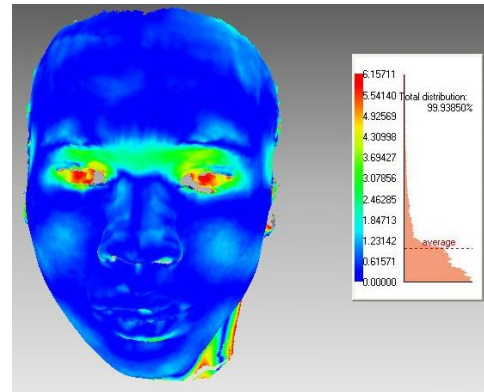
Color plot displaying surface difference of Soft tissue extracted from laser scan data and soft tissue reconstructed from CT data
